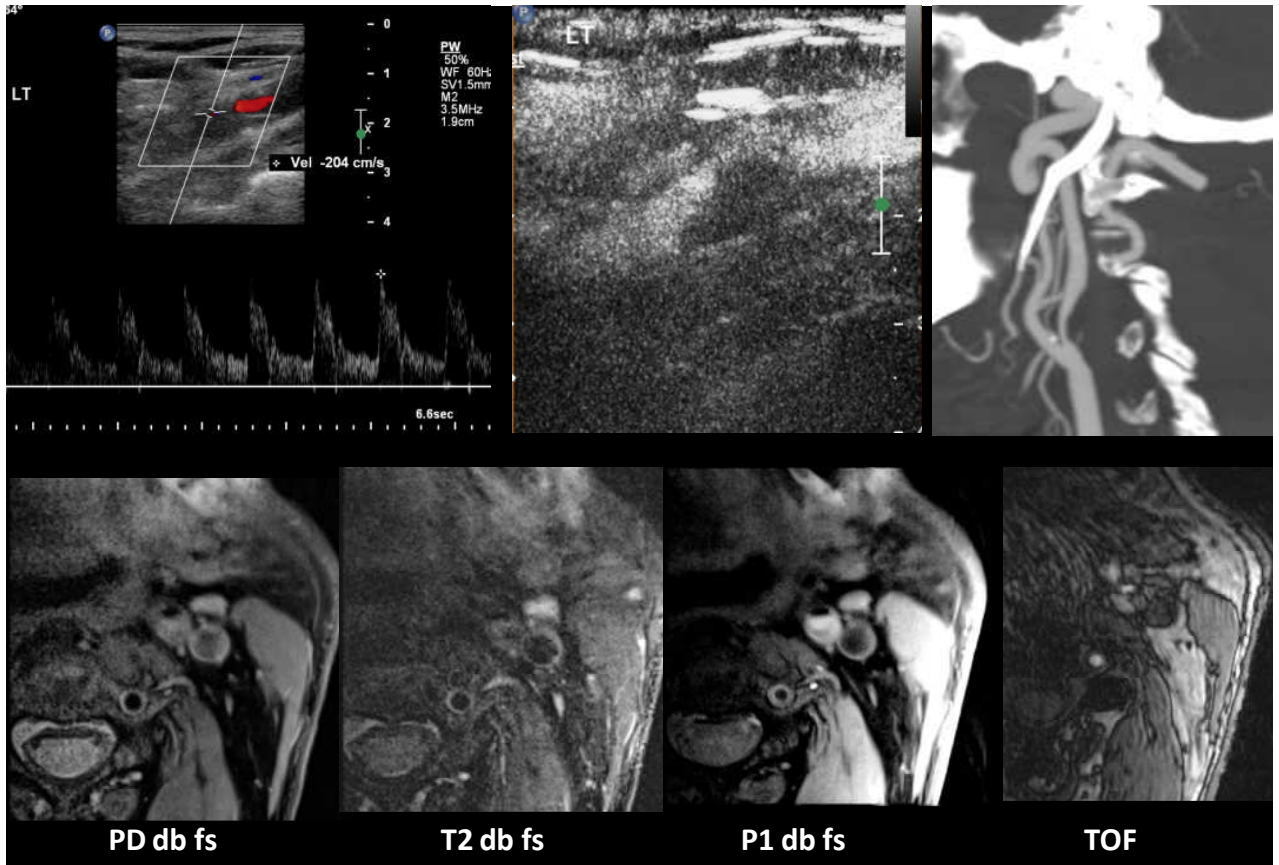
M/ 80 yrs with 4 episodes of left MCA TIAs. Left ICA 80% stenosis. PSV 204 cm/s. No neovascularization is seen on CEUS. On CTA, plaque is hypoattenuating and surface shows a single Type III ulceration. On MRI, plaque appeared isointense on PD, hypointense on T2WI, mildly hyperintense on T1WI and isointense on TOF s/o lipid core. Fibrous cap was well visualized.
